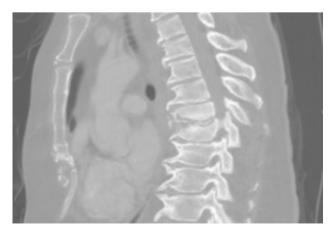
CT image demonstrating T7-8 discitis and osteomyelitis.
